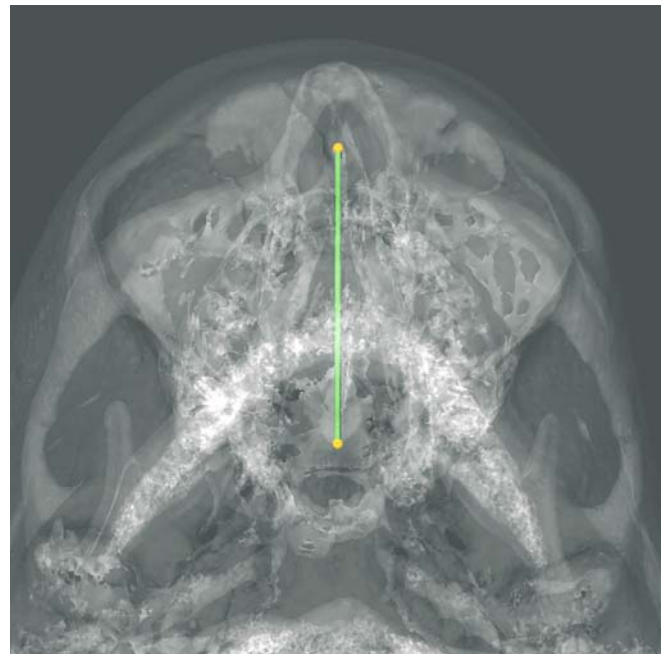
Maxillary length, ANS-PNS (3-D CT, transparent hard tissues, patient K.C.)
